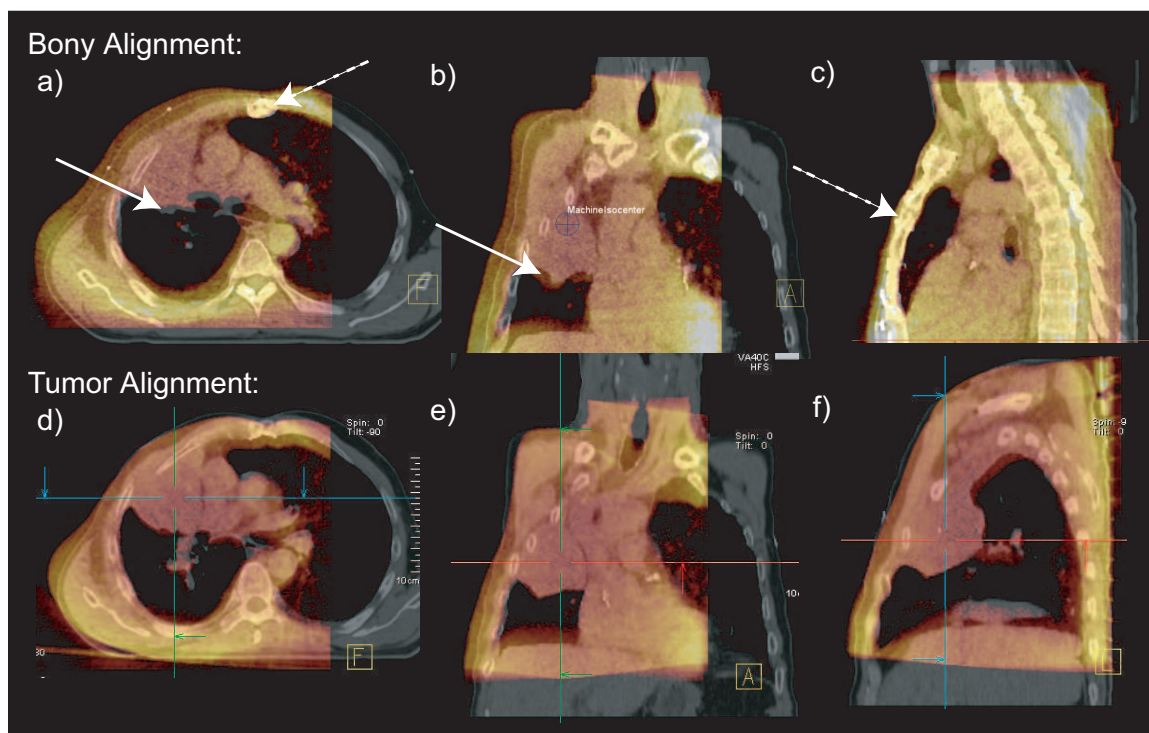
Images comparing the use of MVCBCT and portal imaging for setup of a hypo fractionated lung patient with a large and relatively immobile tumor. On the first fraction, the shift assessment was done using the sternum on portal images. This shift was then applied to a MVCBCT acquired the same day. Three views of the CT (gray scale) fused with the MVCBCT (color) are shown. While the sternum is well aligned on (c) the tumor is not on (a) and (b). For this reason, the patient was aligned using the soft-tissue information on the MVCBCT images.
